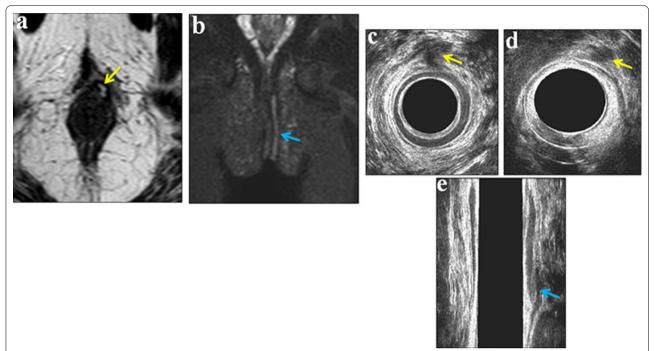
a MRI axial T2 WI images showing left perianal region trans-sphincteric fistulous tract breaching the deep part of the external anal sphincter opposite 1 o'clock (yellow arrow). b MRI coronal STIR WI images showing high signal trans-sphincteric fistulous tract ending just below the inferior margin of the left puborectalis (blue arrow). c, d ultrasound axial images show left hypoechoic trans-sphincteric fistulous tract breaching the subcutaneous and deep portions of the left external anal sphincter at 12–1 o'clock (yellow arrows). e Post reconstruction ultrasound coronal images show left trans-sphincteric fistulous tract breaching the deep and superficial portions of the external sphincter (blue arrow)
